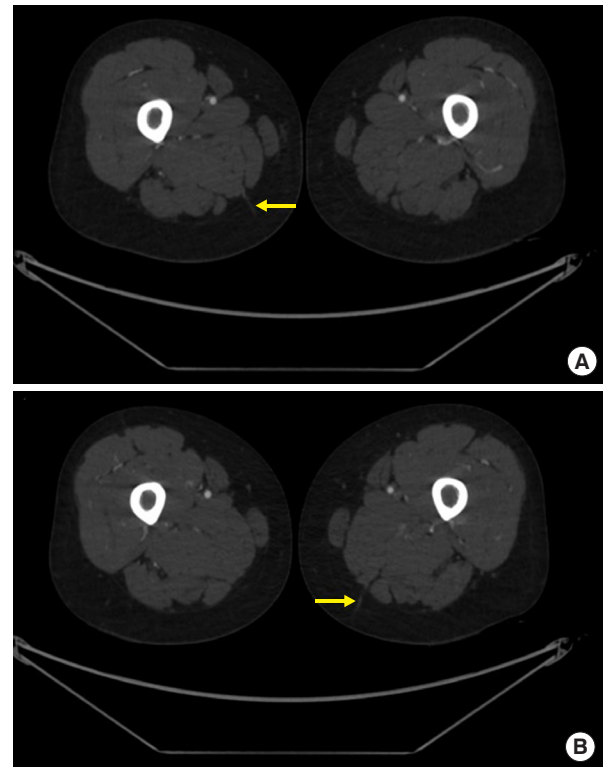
(A) Preoperative lower extremity computed tomography angiography revealing a right profunda artery perforator (arrow) and (B) a left profunda artery perforator (arrow).
